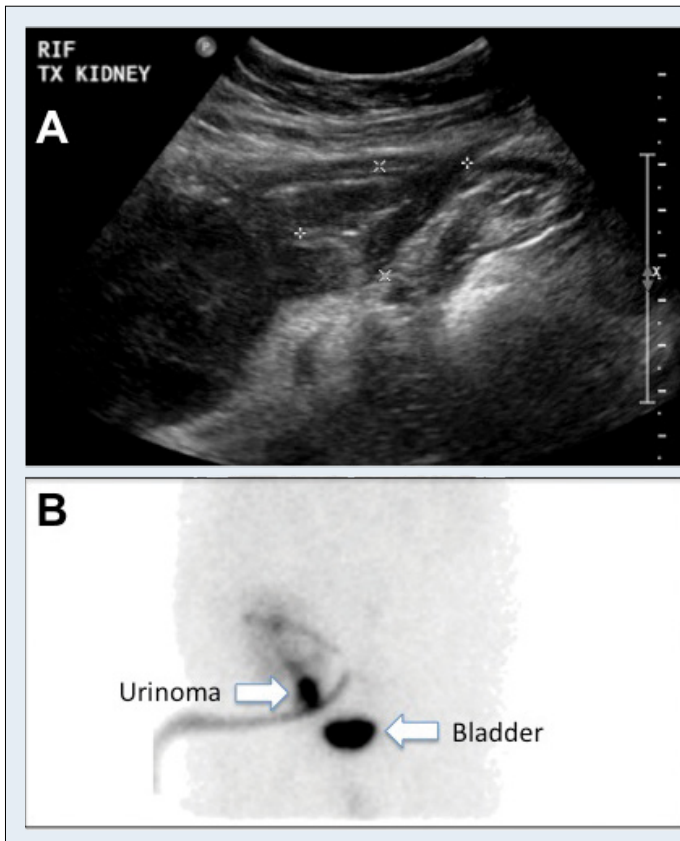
(A) Renal transplant ultrasound revealing a complex perinephric collection. (B) Renal MAG3 scan showing an active connection between the perinephric collection which is secondary to a urine leak and the urinary tract with the tracer seen through the inserted drain tube catheter.
